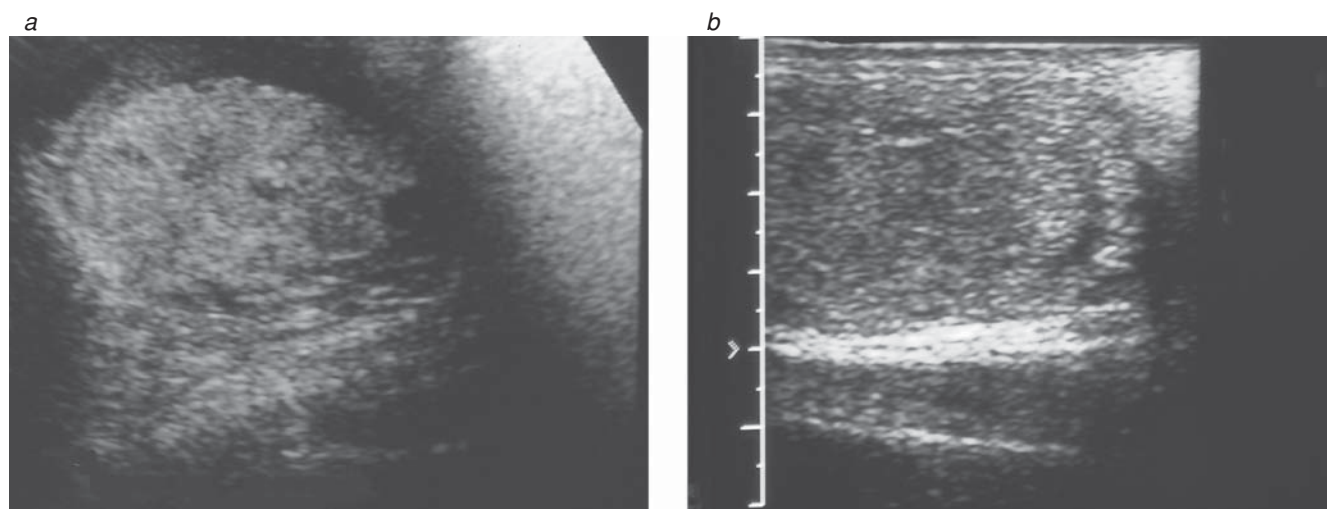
(a) Ultrasonogram of ruptured testes shows intraparenchymal hematoma and heterogeneous echotexture. (b) Ultrasonogram of ruptured testes shows indistinct testicular contour and abnormal echotexture.
